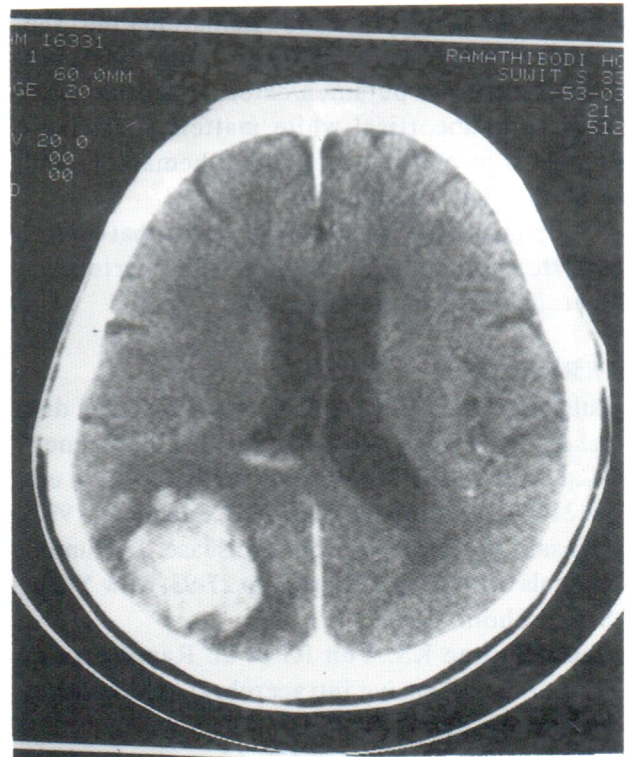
CT shows hematoma in the right parieto-occipital subcortical area and thin layer of blood in right lateral ventricle
